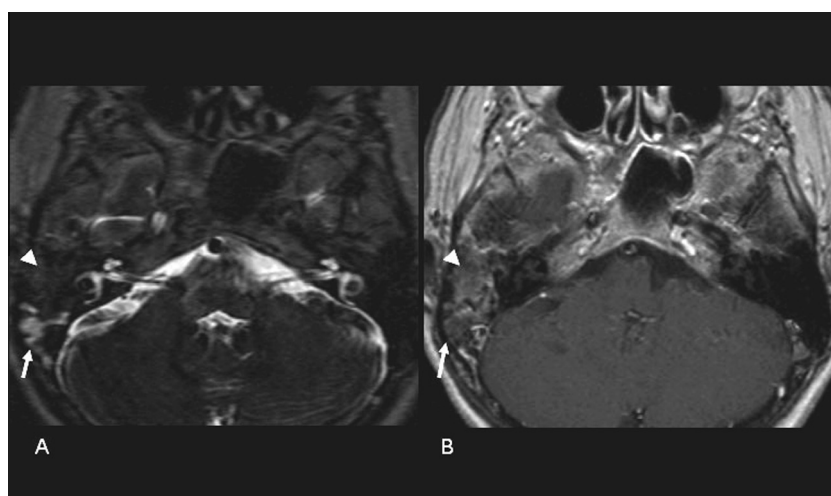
(A) Axial T2-weighted scan (TR/4000 ms, TE/250 ms) demonstrating a low signal intensity tissue (white arrowhead) occupying a large part of the right mastoid. Mastoiditis at the periphery of the lesion appears with high signal intensity (white arrow). The inner ear components appear normal with the expected high signal. (B) Axial contrast enhanced T1-weighted scan (TR/500 ms, TE/20 ms) same level with (A) demonstrates an enhancing tissue (white arrowhead) occupying a large part of the right mastoid. Mastoiditis at the periphery of the lesion appears with intermediate signal intensity (white arrow). No contrast enhancement was observed at the inner ear.
